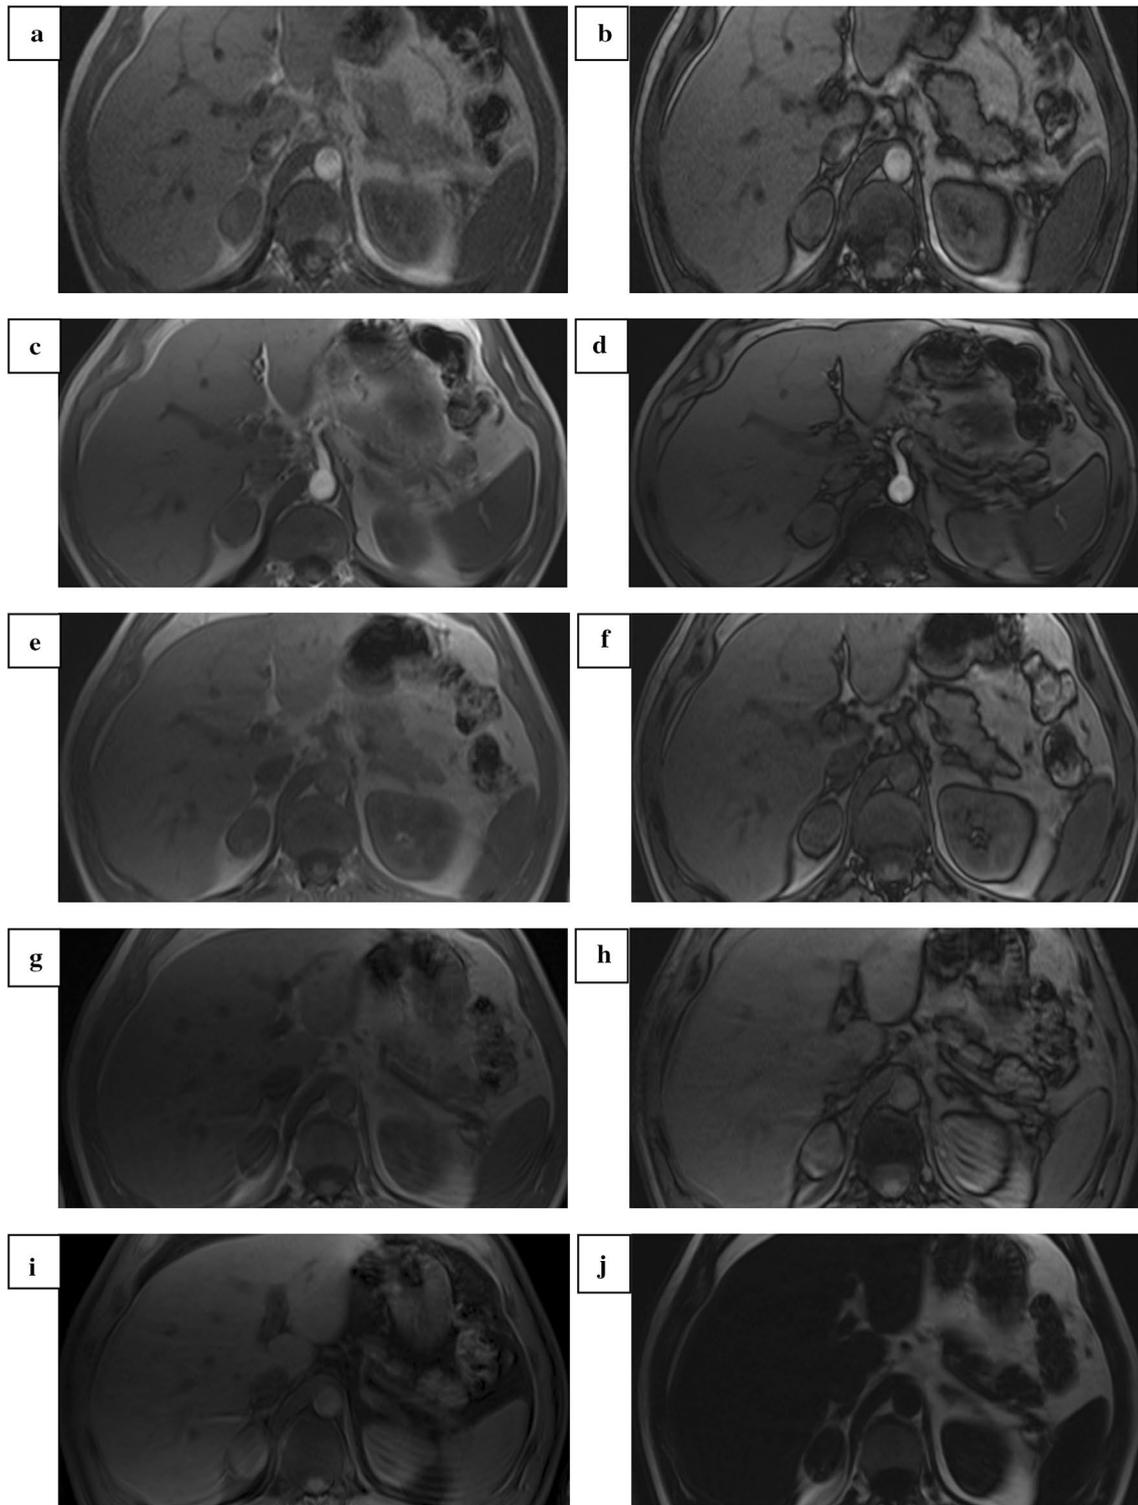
A 56-year-old woman with an incidentally discovered lipid-poor right adrenal adenoma, which was confirmed with unenhanced and contrast-enhanced CT (with an attenuation value of 26 HU on unenhanced CT and 61% absolute wash-out on contrast-enhanced CT). Afterward, the patient was followed up with MRI. The IP (a) and OP (b) images of the 2D dGRE technique at 1.5 T are the only
